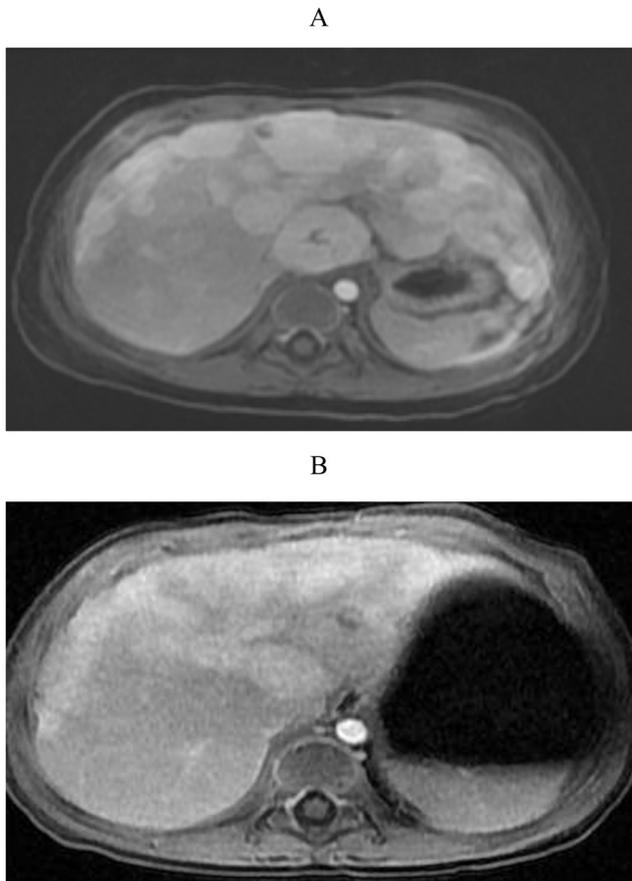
MRI of the liver 4 months (A) and at 8 months (B) post discontinuation of steroid therapy.
